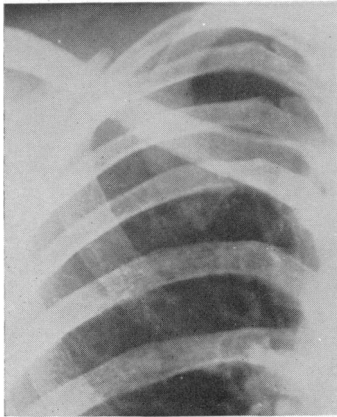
Case 2. Radiograph of upper zone of right lung, January, 1956, showing localized tuberculosis.
